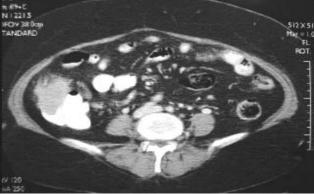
Carcinoma of the ascending colon (A). Tumor necrosis & extramural spread were correctly identified on the CT scan.
